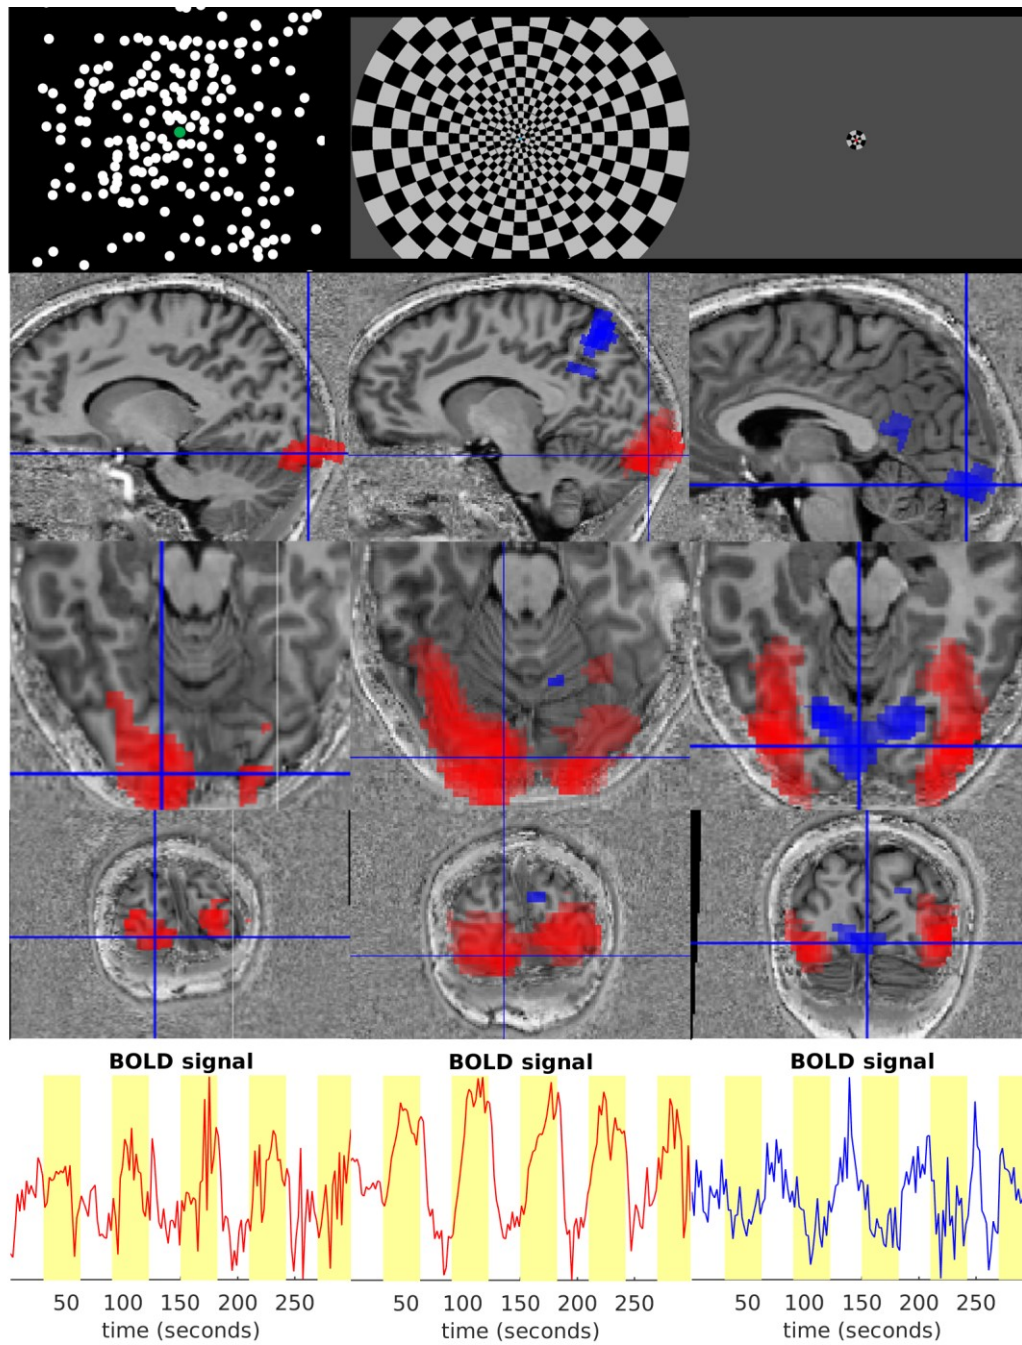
BOLD activation maps and time courses with the three visual stimuli (TOP) used on a representative volunteer (female, 26 years old, 7 T). LEFT, CENTER, and RIGHT columns correspond to the moving stars, flickering checkerboard and small flickering checkerboard respectively. PBR is shown in red and NBR in blue. Overlays with the activation maps and T1-weighted mp2rage anatomical images are shown on sagittal, transversal and coronal slices for the three stimuli. Yellow boxes on the time courses indicate when the stimulus was presented (BOTTOM).
